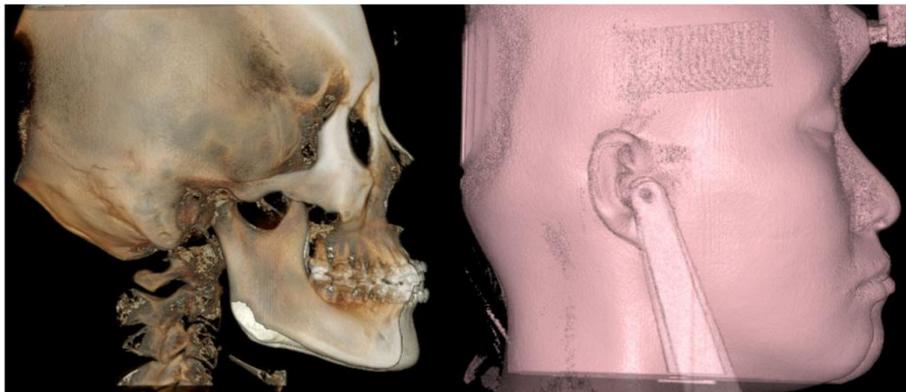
Superimposition of 3-dimensional cone-beam computed tomography images of the hard and soft tissues using OnDemand software.
